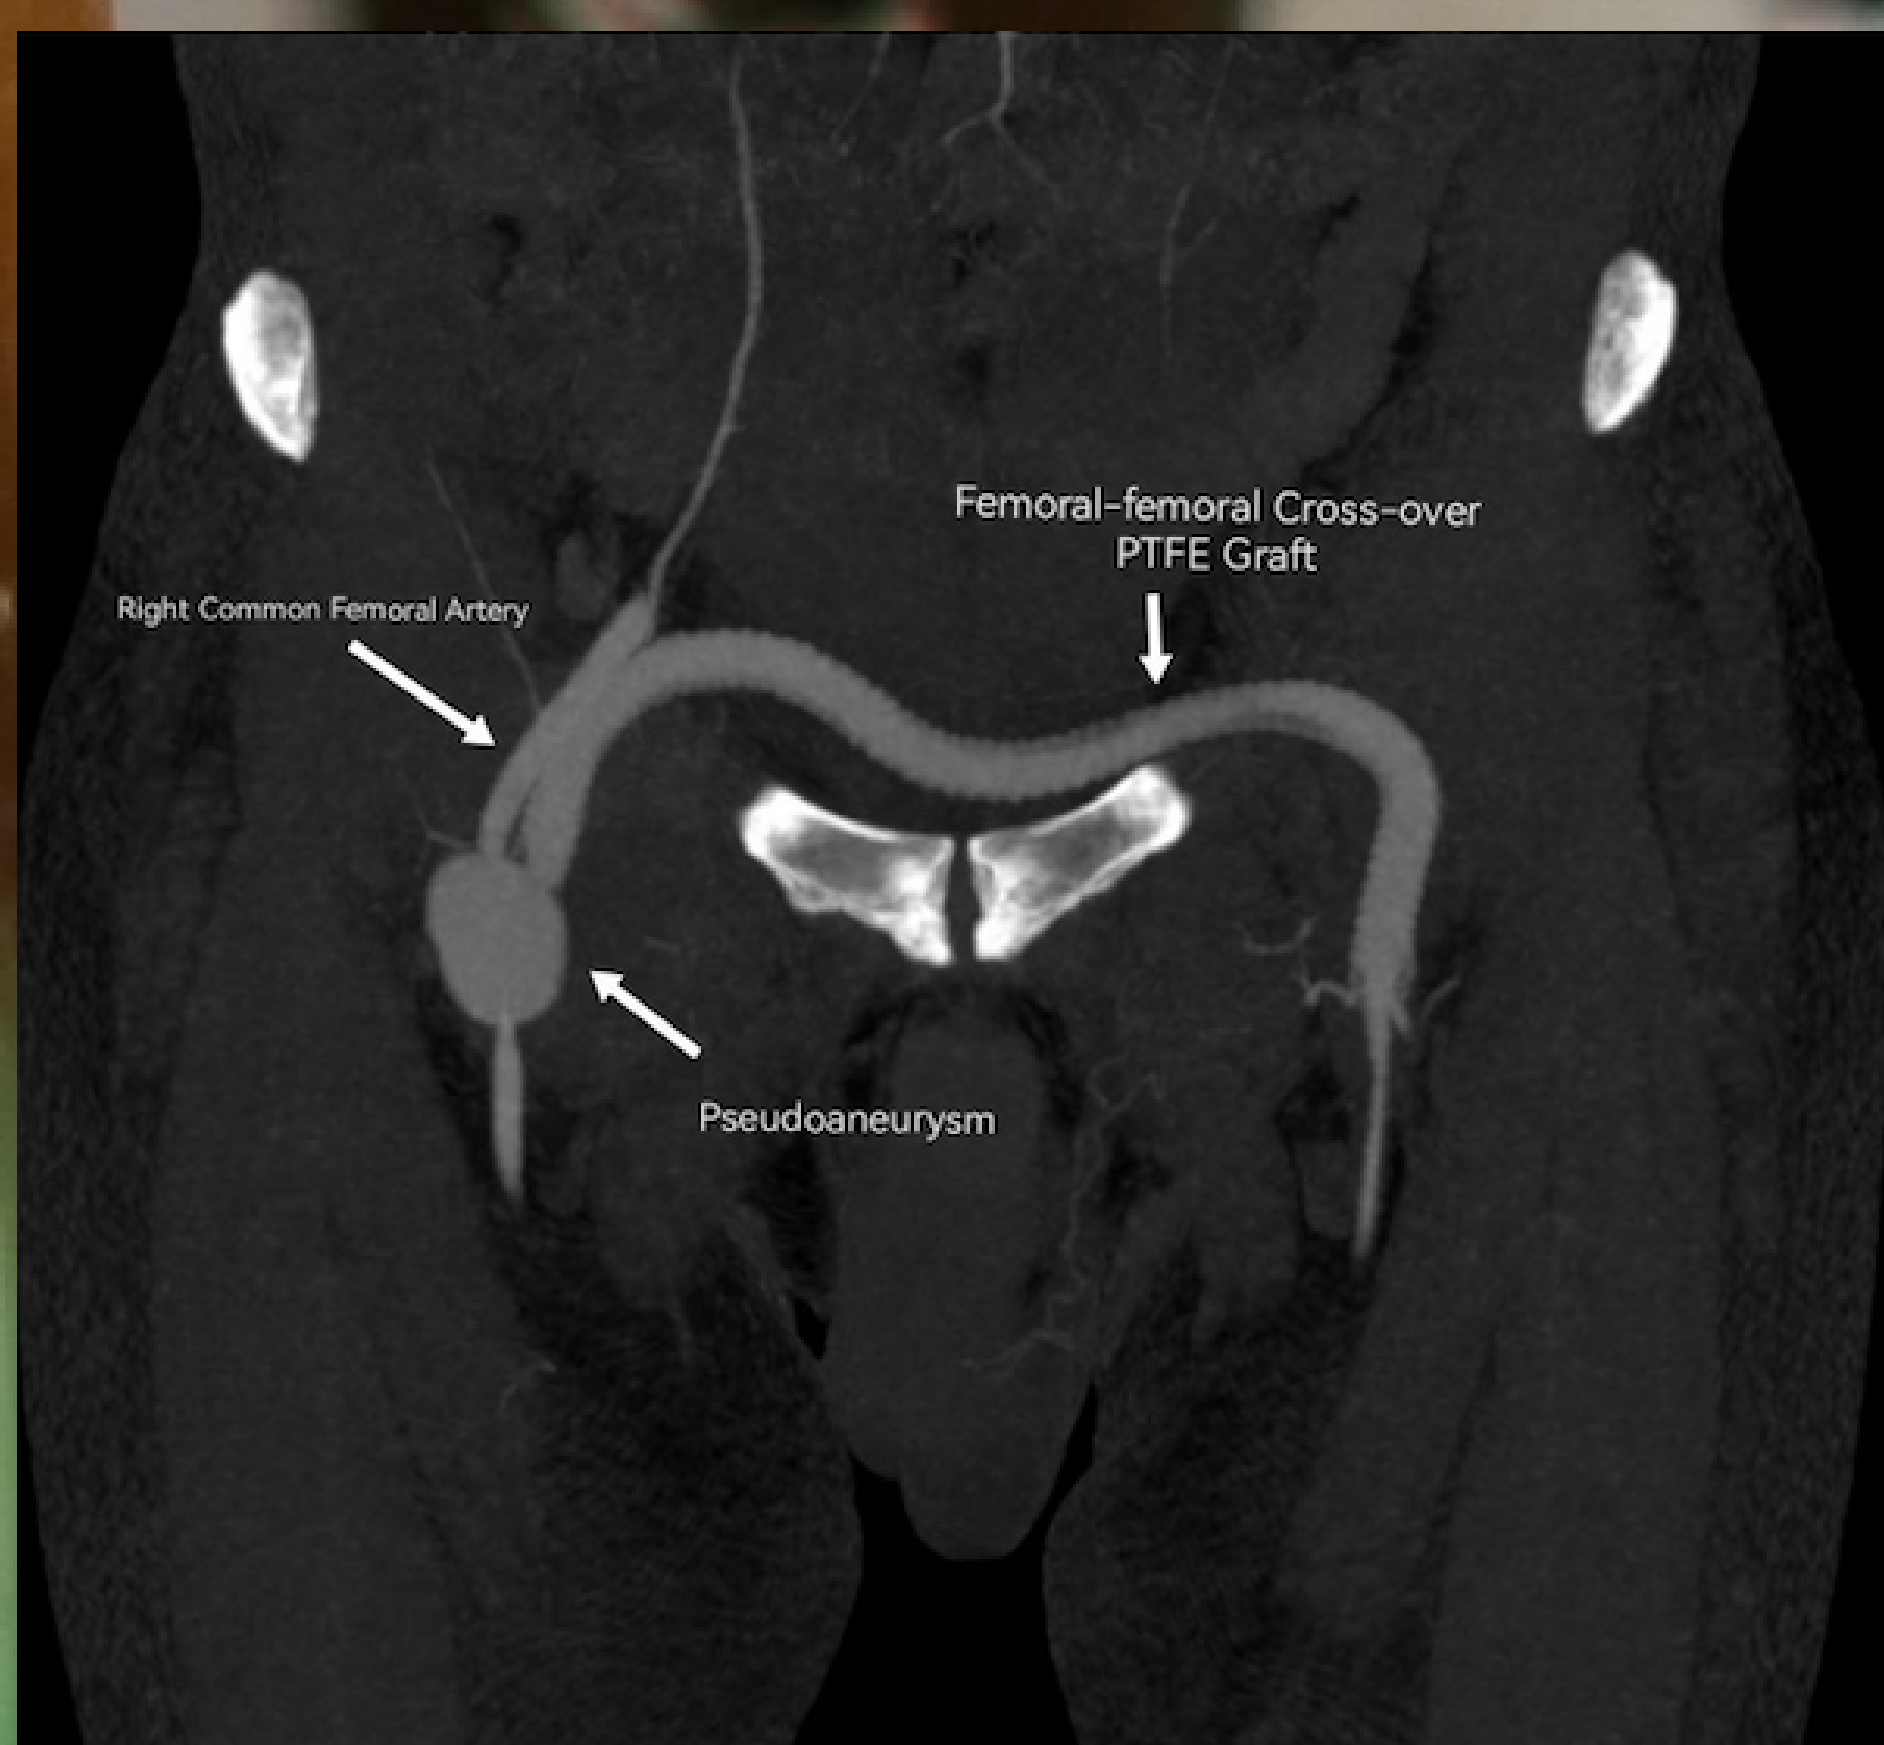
Maximum intensity projection (MIP) of CT angiogram bilateral lower limbs in coronal section showing a pseudoaneurysm arising from the junction of the right common femoral artery and femoral-femoral cross-over PTFE graft.
